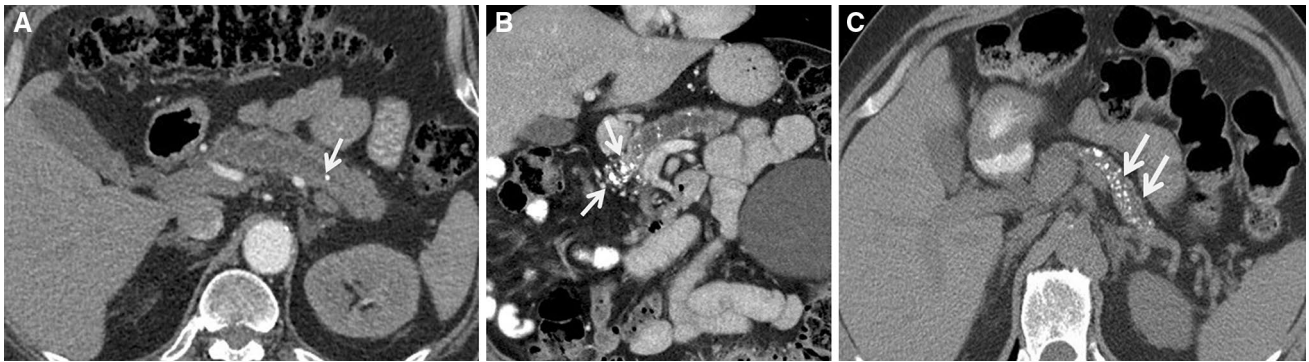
Pancreatic calcifications: axial and coronal CT scan showing <7 punctate (a), 7–49 punctate calcifications (b), and more than 50 punctate (c)
